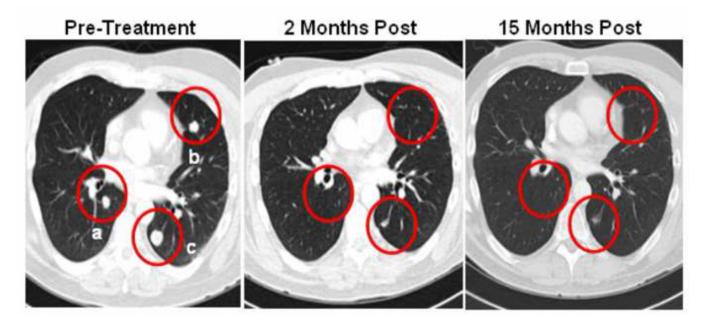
Lymphodepletion and ACT induced regression of metastatic disease in the lungs, with a small degree of radiographic residua indicative of a partial response. In the pretreatment scans, (a) measured  $1.3~\rm cm \times 1.0~\rm cm$ , (b) measured  $1.1 \times 0.8$ , and (c) measured  $2.0 \times 1.5~\rm cm$ . In the post-treatment scans, all lesions were less than  $1.0~\rm cm$ .
